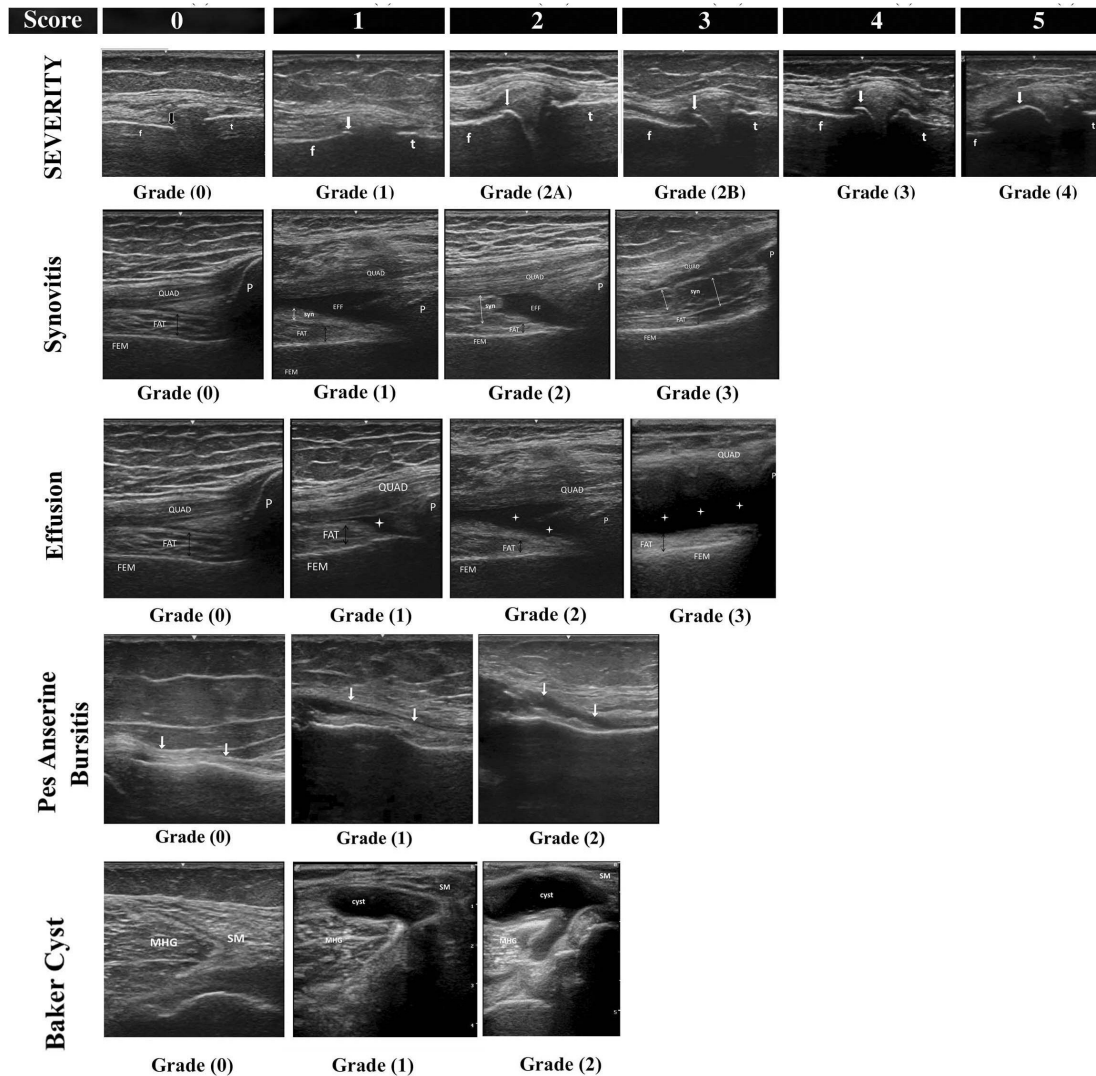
Domains of ZAGAZIG ultrasonographic scale for knee osteoarthritis with its corresponding scores. f (Fem); femur, t; tibia, P; patella, Fat; fat bad (double headed black arrow), EFF(star); effusion, syn; synovitis (double headed white arrow).
